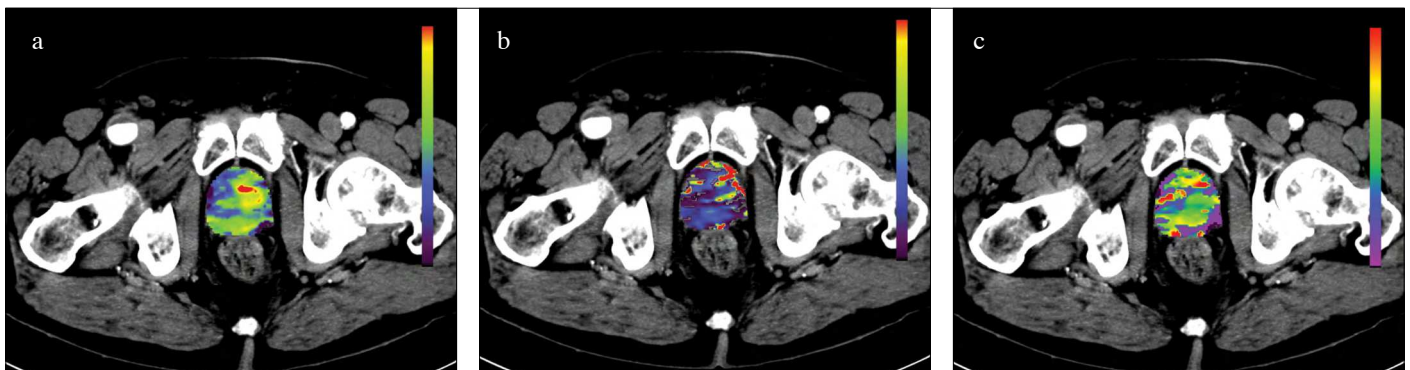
a-c. Computed tomography (CT)-perfusion imaging of one patient with prostate cancer, Gleason score 7 (3 + 4). (a) Colour-coded map of perfusion parameter blood flow (BF) (28.5 $\text{mL}/100 \text{ mL min}^{-1}$; scale 0-40); (b) blood volume (BV) (4.1 $\text{mL}/100 \text{ mL}$; scale 0-15) and (c) mean transit time (MTT) (8.1 seconds, scale 0-40)
